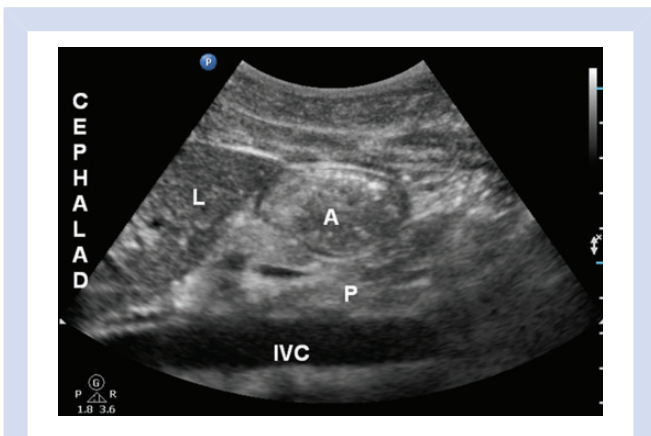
Sonographic image of the gastric antrum of an empty stomach. Note the antrum appears small, with no visible content. The muscularis propria is seen distinctly as a thick hypoechoic layer of the gastric wall. A, antrum; L, liver; P, pancreas; Ao, aorta.
